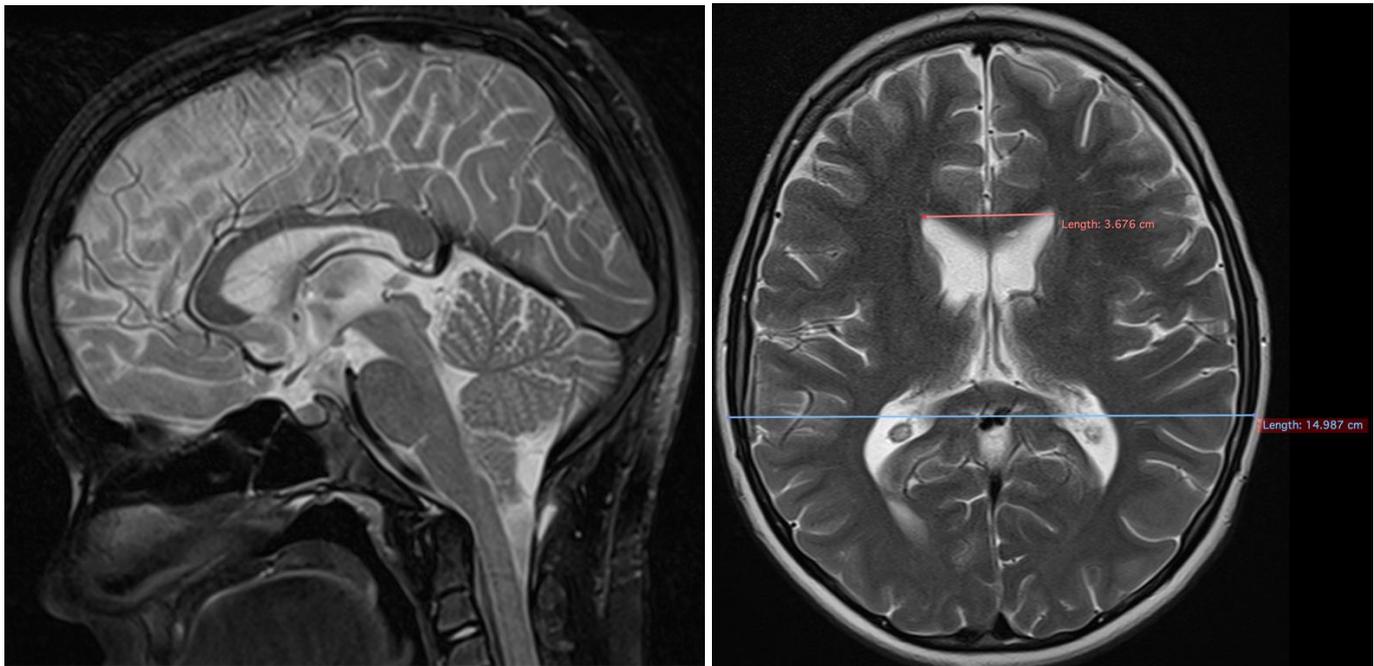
a) Sagittal cisterna magna and resolution of ventriculomegaly, PMC and infratentorial hygromas. Evans index 0.24. b) axial T2-weighted MRI scans 1 month after readmission showing a restored cisterna magna and resolution of ventriculomegaly, PMC and infratentorial hygromas. Evans index 0.24.
